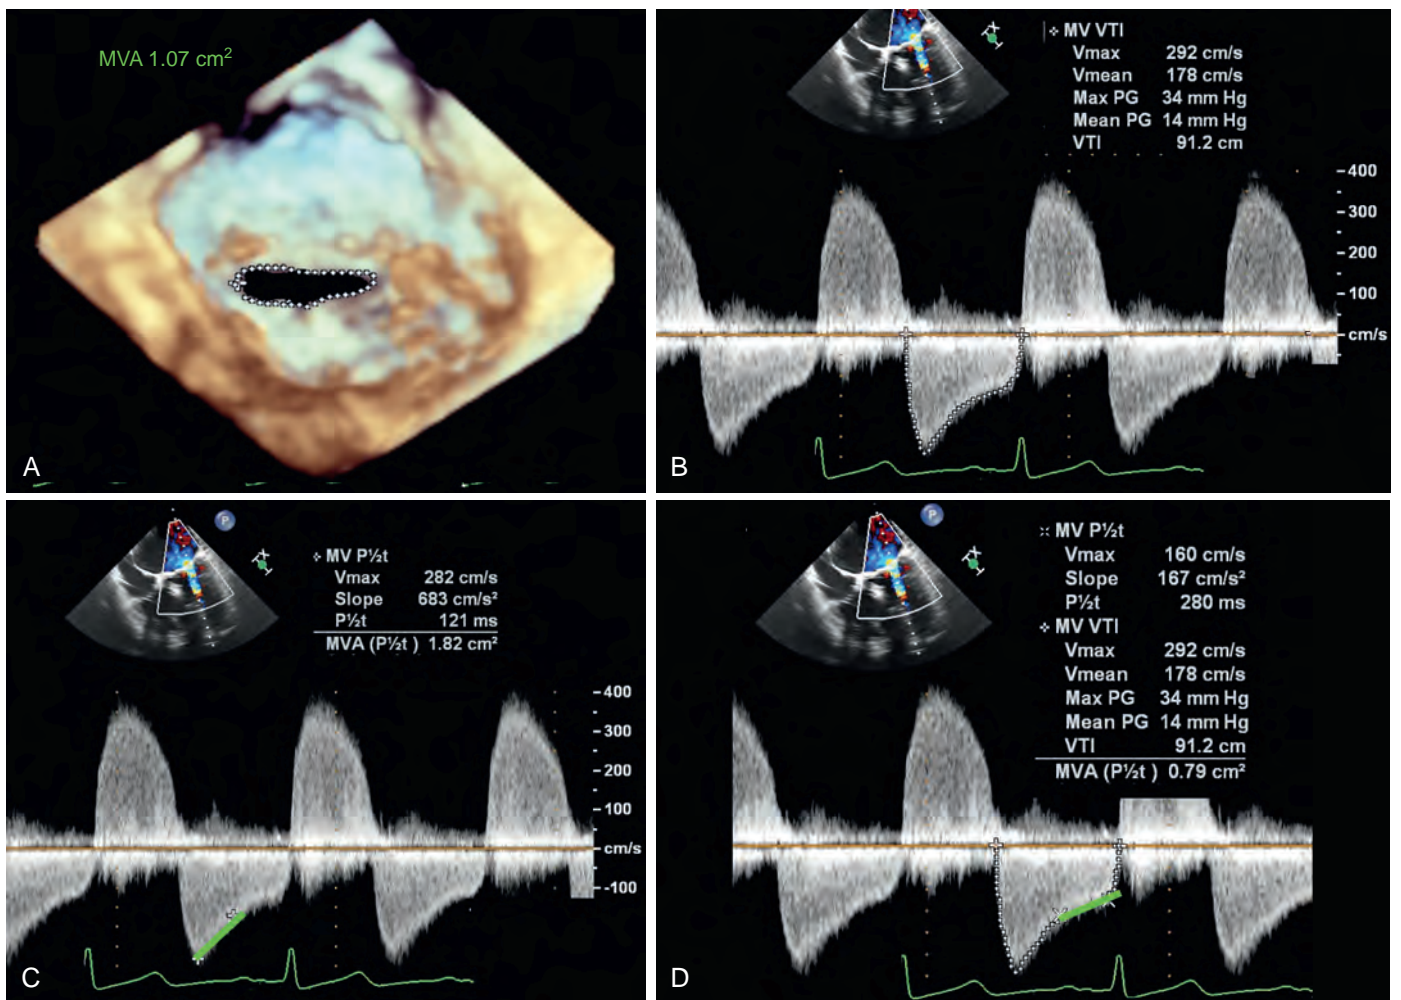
Assessment of mitral stenosis (MS). Pressure gradients, pressure half time (PHT), and planimetry are the common assessments of the mitral valve area (MVA). (A) Planimetry is performed from the three-dimensional view of the mitral opening seen from the left ventricular perspective. (B–D) Doppler profiles of flow across the valve. It is evident that mitral regurgitation coexists as seen by the upward systolic flow. Based on the downward deflection, MS also exists. The peak and mean gradients are 34 and 14 mm Hg, respectively. The forward flow profile across the valve, however, is biphasic. If the PHT were based on the initial phase, the MVA would be 1.82 cm^2 . However, if based on the latter phase, the MVA would be 0.79 cm^2 . Since the initial phase may represent initial opening velocity resistances, flow, and cardiac output, it is recommended to use the latter phase because it represents a more stable flow state and a better reflection of the effective orifice area.
